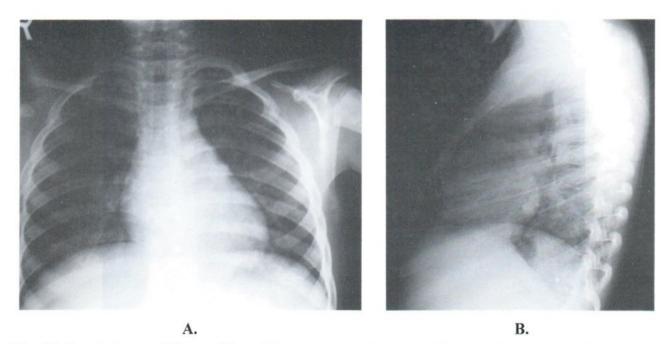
A 5 year old boy with positive tuberculin test. PA and lateral chest radiographs show reticulo-nodular infiltration in RLL. with bilateral hilar adenopathy.
